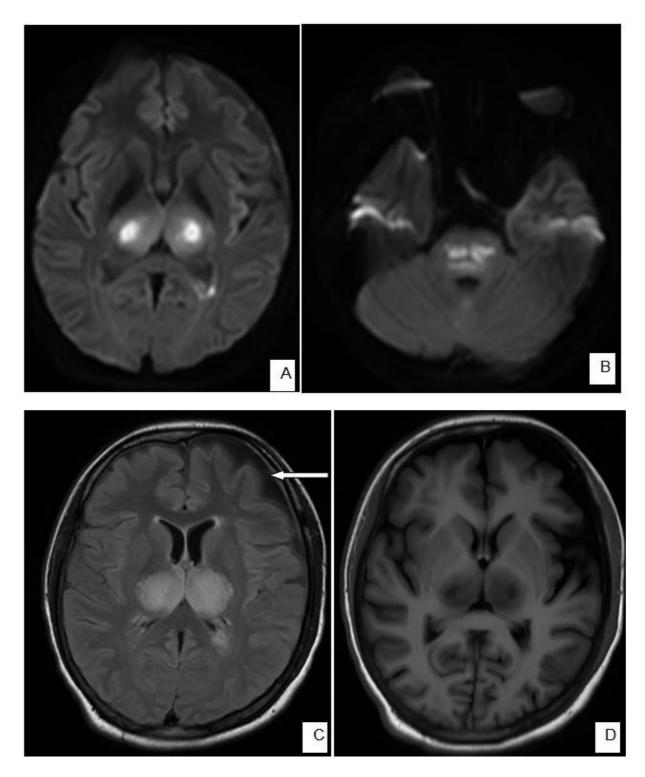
A 22-year-old female patient in post COVID-19 status with suspected meningoencephalitis, underwent MR imaging and multifocal near-symmetrical acute infarcts were noted in the supra and infratentorial brain parenchyma, a diagnosis of acute necrotizing encephalitis was made. [A and B] shows acute infarcts in bilateral thalami and pons with high DWI intensities, [C] shows corresponding T2 hyperintensities in bilateral thalami. Incidental left frontal subdural hygroma was also noted (white arrow). [D] shows central intense T1 hypointensity, representing necrosis.
